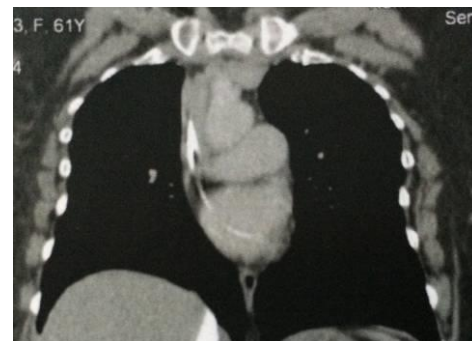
CT scan showing deep advancement of the CVC into right ventricle.
